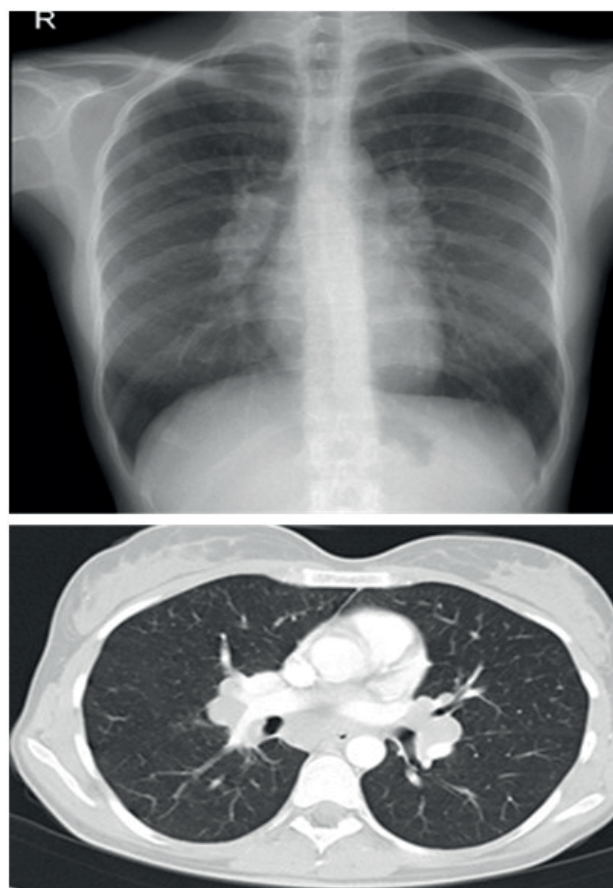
The x-ray and computed tomography of thorax in a patient presenting with bilateral hilar lymphadenopathy (stage 1 sarcoidosis) and also breast involvement
